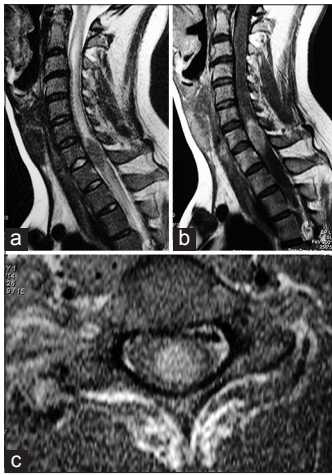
Magnetic resonance images of the cervical spine demonstrating a well-defined oval intramedullary lesion expanding the spinal cord at C7–Th1. (a) Sagittal T2-weighted-images demonstrating a well-defined hypointense mass causing an important edema above and under it. (b) Homogenous gadolinium enhancement is evident. (c) A predominant anterior location within the spinal cord is observed on axial images after the application of gadolinium
